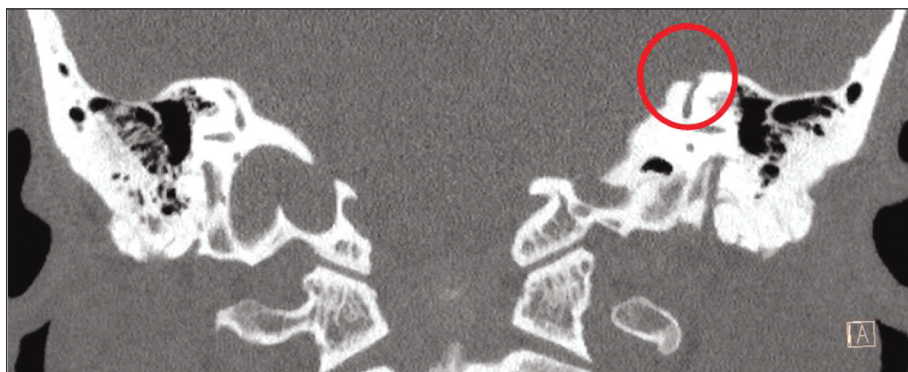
The high-resolution computed tomography scan of the temporal bone of Case 4.
